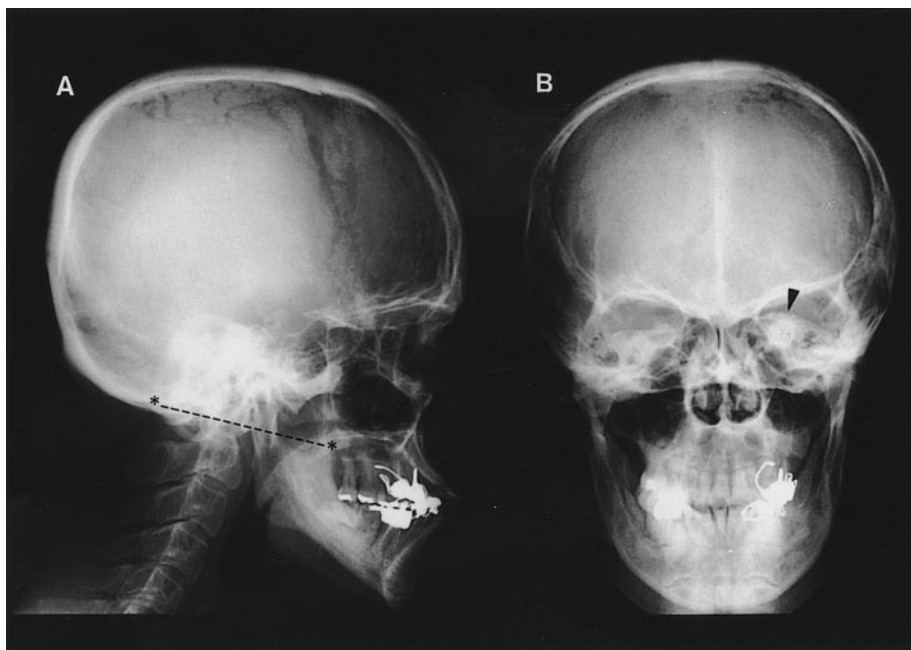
(A) Lateral skull radiograph showing basilar impression and atlanto-occipital assimilation. The odontoid process was found to be lying far above Chamberlain's line (*-----*), which is defined as a straight line drawn from the posterior margin of the hard palate to the posterior margin of the foramen magnum. (B) Anteroposterior radiograph revealing the marked elevation of the left petrous bone (arrowhead)
